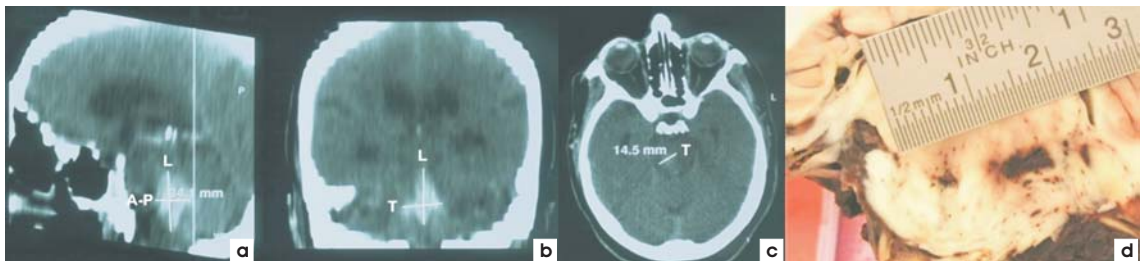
Large brain stem hematoma: (a), (b), (c) CT images; (d) necroptic aspect
